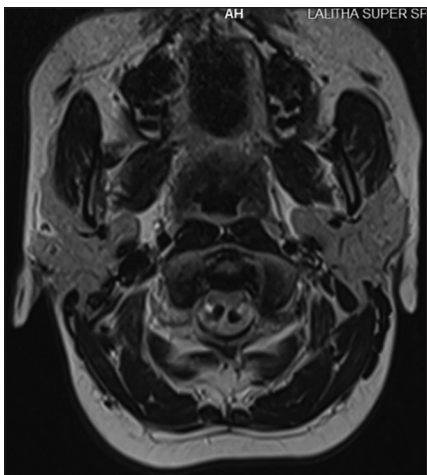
Axial T2 MRI image with CVJ compression
